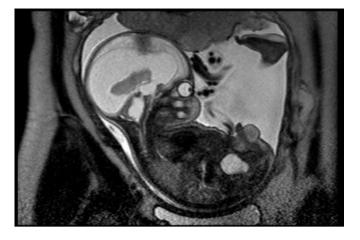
T2-weighted coronal magnetic resonance image of fetus MRI at 27 weeks 2 days.
